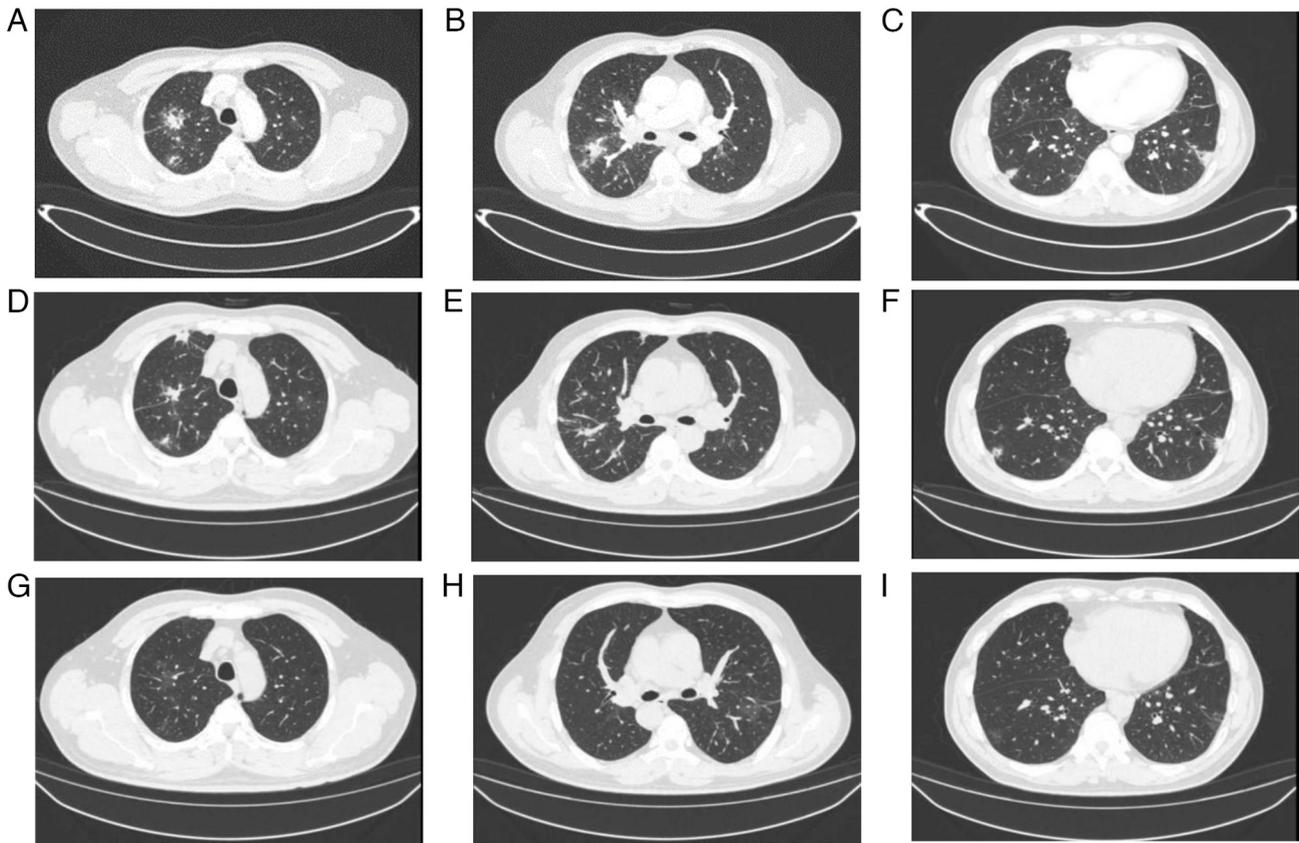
Comparison of chest CT in patient 1. (A-C) Chest CT in July 2023. (D-F) Chest CT 2 weeks later. (G-I) Chest CT in August 2023. The lesions were more clearly absorbed in August compared with at the first CT scan in July.
